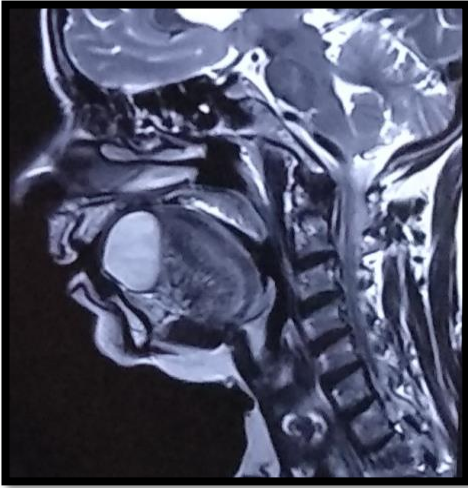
MRI- Sagittal Section.
